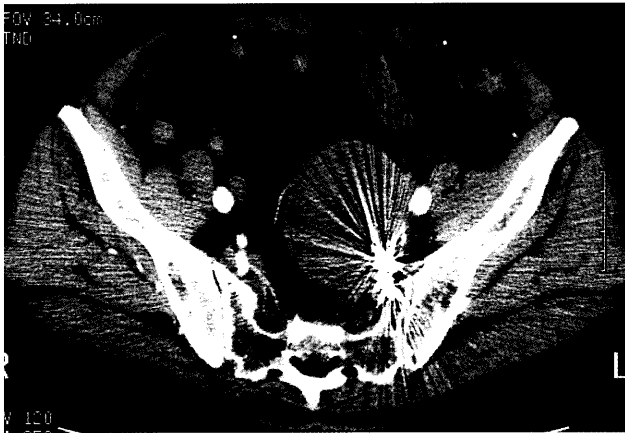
Pelvic CT scan obtained 3 months after the stent-grafting demonstrates no contrast opacification within the aneurysm.
